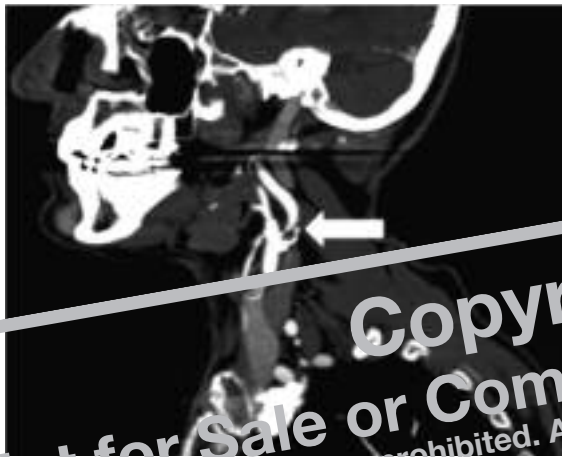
CTA Reformat Showing 90% Left ICA Stenosis.
